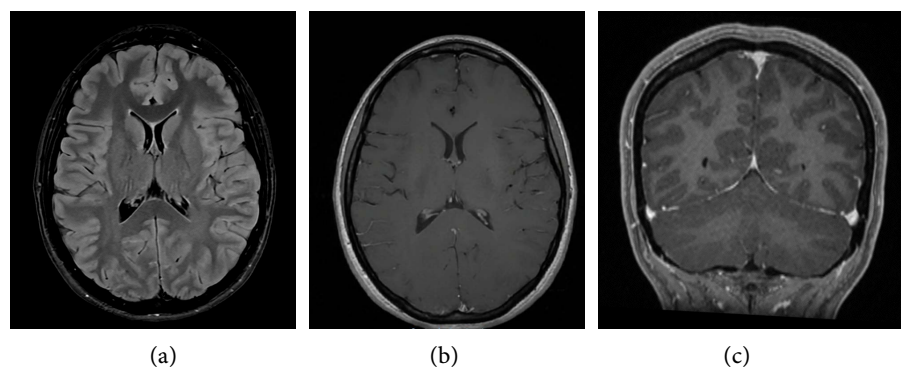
CT scan without tumor activity.
